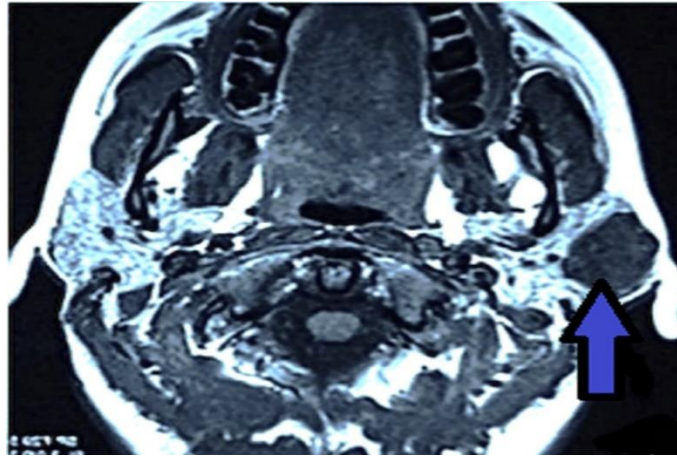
Axial T1-weighted MRI without contrast showing a well-circumscribed isointense mass (blue arrow) in the superficial lobe of the left parotid gland
